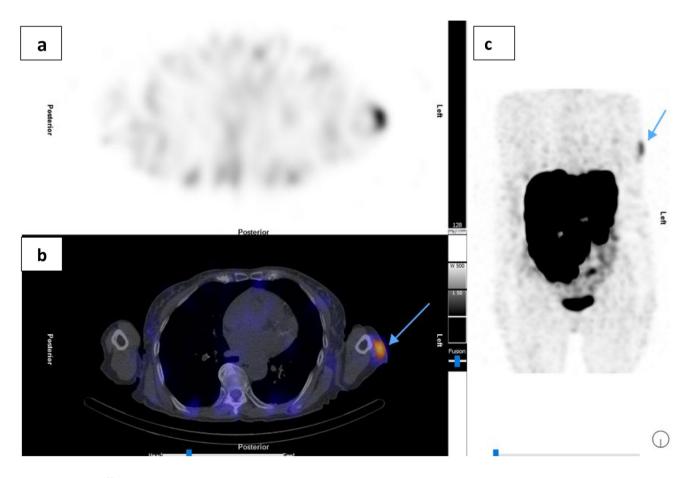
Patient A: [¹⁷⁷Lu] Lu-DOTA-TATE Cycle 3 post-therapy SPECT/CT. a Transaxial SPECT; b Fused transaxial SPECT/CT; c SPECT Maximum intensity projection (MIP) showing focus of increased uptake localized to the left deltoid (tip of blue arrow)
